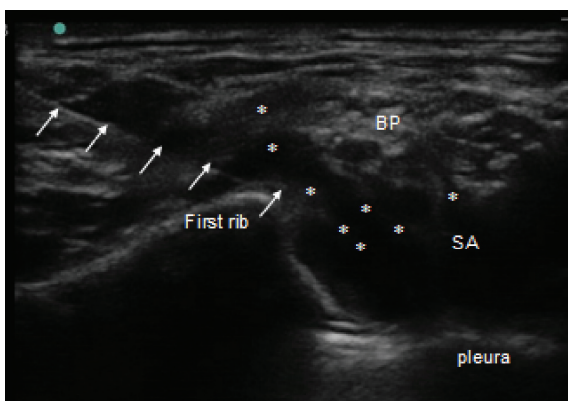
Sonographic image of spreading of local anesthetic solution around the brachial plexus (arrow: needle, BP: brachial plexus, SA: subclavian artery, *: local anesthetic solution).
